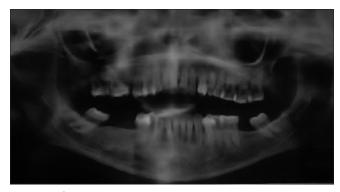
Orthopantomograph showing radiolucent changes in the mandible.
